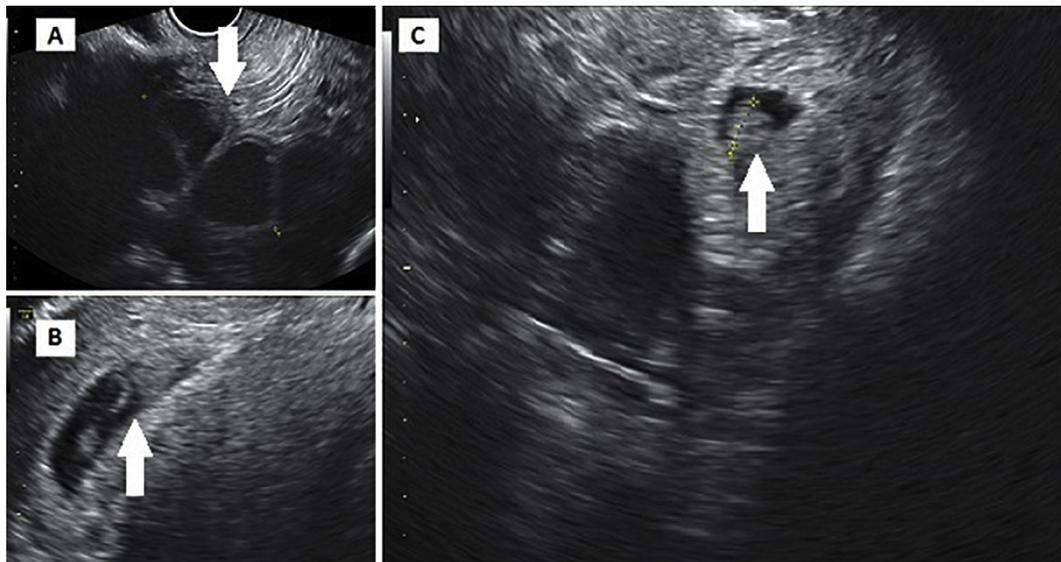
Transvaginal ultrasound images of heterotopic pregnancy and ovarian hyperstimulation: (A) enlarged left ovary with multiple cysts measuring 10 cm × 10 cm; (B) mass of mixed echogenicity in the uterine cavity; (C) gestational sac in the left adnexal region with viable pregnancy, crown–rump length (CRL) 6.6 mm at 6 weeks of gestation.
